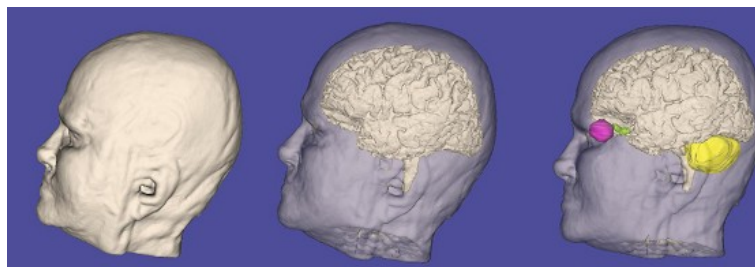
Reconstructed 3D model from MRI data sets with segmented structures.*
